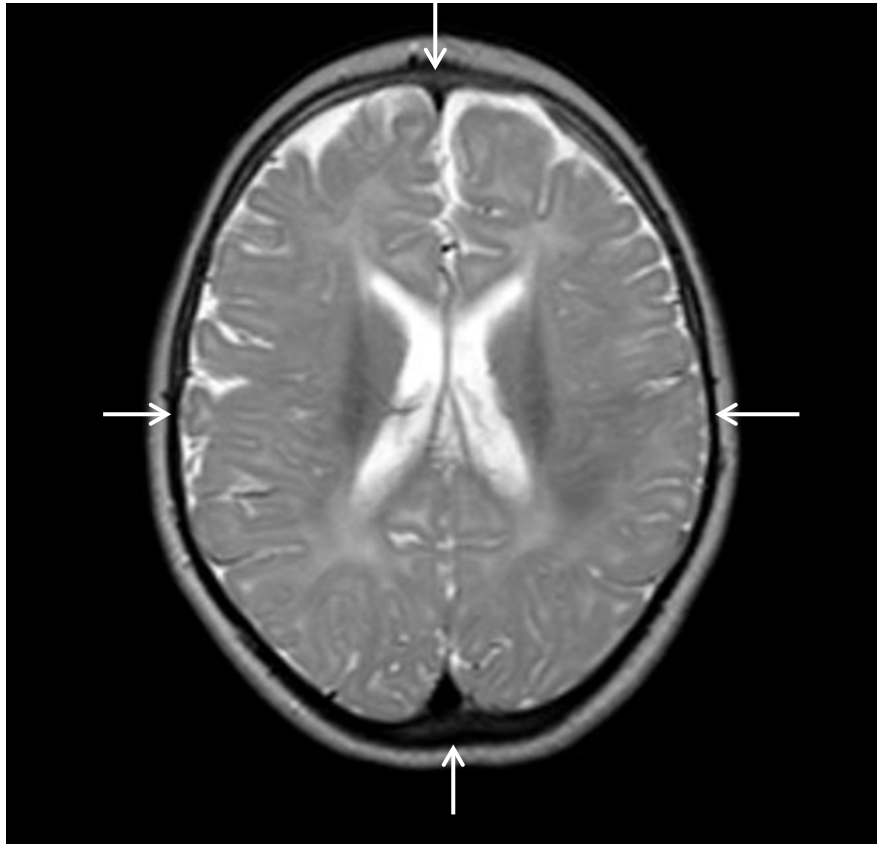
(A) MRI brain scan of IV.1 at 3 years. The axial transverse weighted image (A) shows global reduction in white matter volume, as indicated by the white arrowheads, and a compensatory increase in extra-axial CSF space depth.
